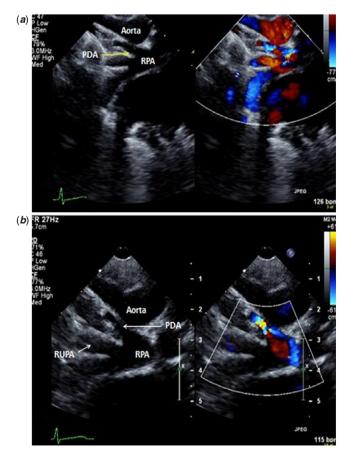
(a and b) A 2-D transthoracic echocardiography showed a right-sided patent ductus arteriosus (PDA) draining to the right pulmonary artery (RPA). RUPA = Right upper pulmonary artery.
